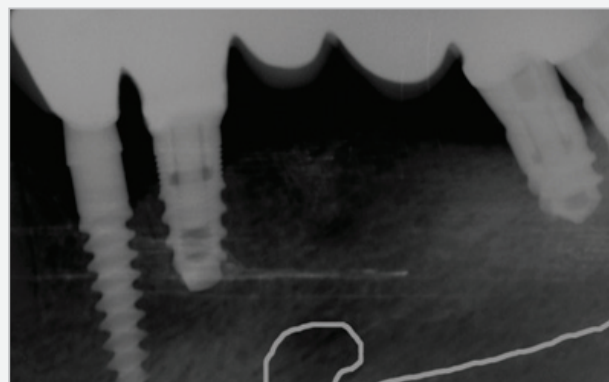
Case 3 - Intraoral x-ray at 6 months after bridge fixation. See the direction of the mandibular nerve.
